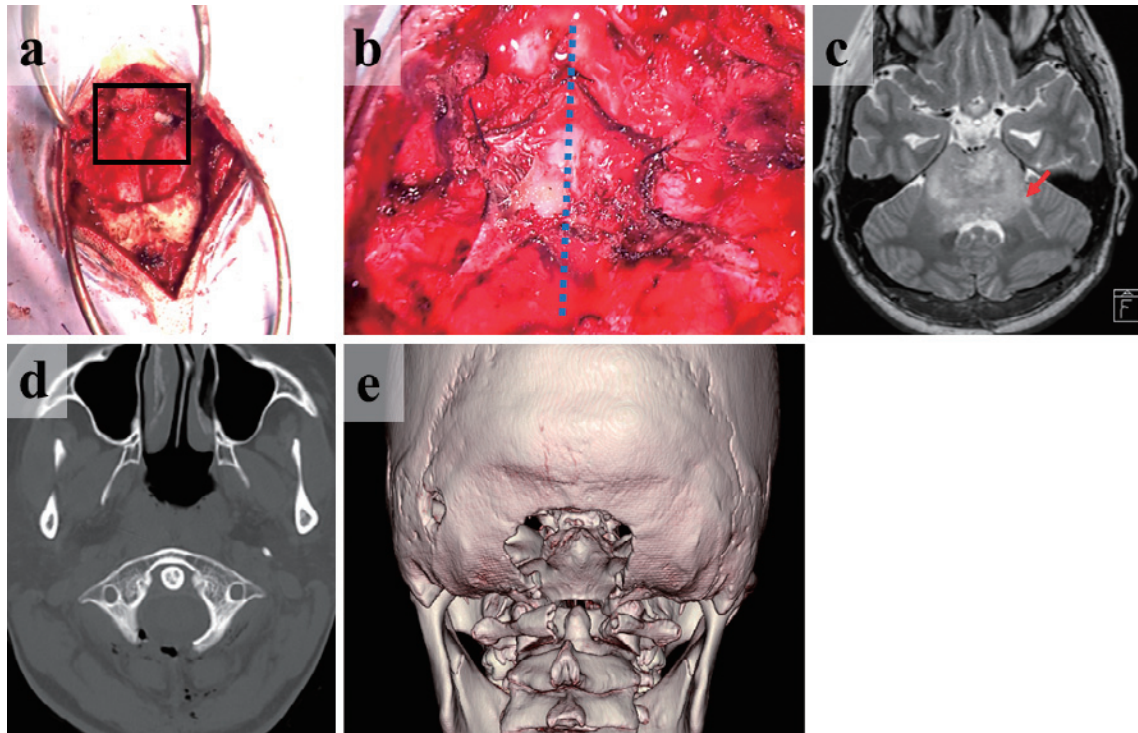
Intraoperative findings and postoperative images. a: A midline suboccipital craniotomy was performed in the supine position and the C1 vertebral arch was resected. The square indicates the area Fig. 2b indicates. b: The epidural layer was decompressed through a midline incision as much as possible. The blue dotted line indicates the median line. c: Postoperative MRI image of T2-weighted. The arrow indicates the biopsied area. d, e: Postoperative CT and CT reconstruction showing the minimal extent of craniectomy and laminectomy.
